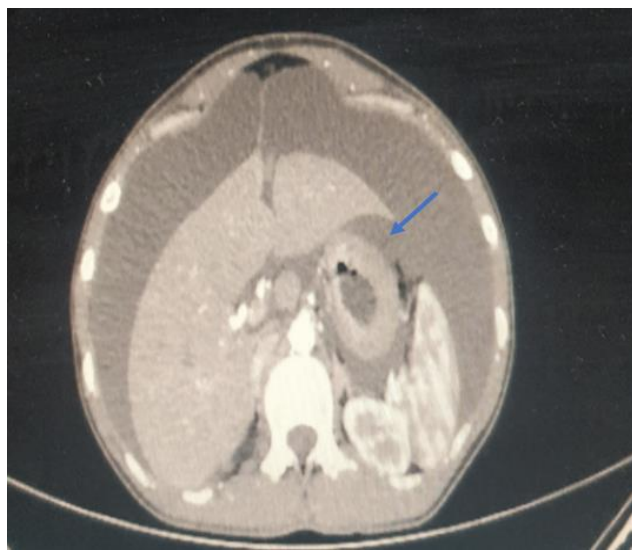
CT scan revealed thickening of the stomach wall suggestive of linitis plastica.
